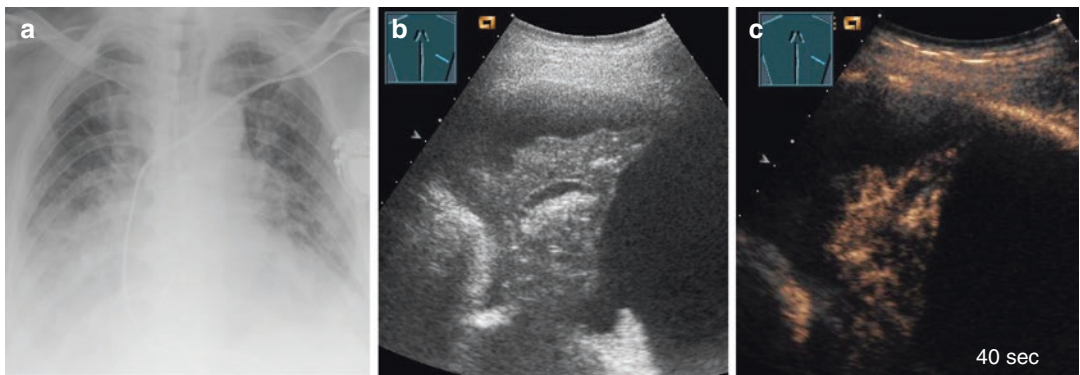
Patient with colorectal cancer and a marked right-sided pleural effusion with compressive atelectasis on CT scan (a); B-mode imaging presents pleural effusion
